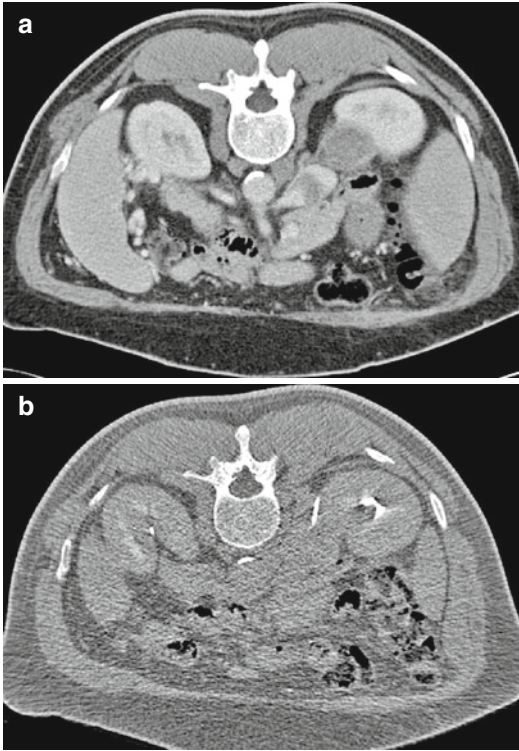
Patient (prone position) with a known hepatocellular carcinoma (HCC). The preinterventional CT showed a suspect mass of the right adrenal gland (a). A posterior right paravertebral approach was chosen for aspiration biopsy with a 19-G (13-cm) needle under CT-fluoroscopic guidance (b). Cytology revealed an adrenal metastasis of HCC
